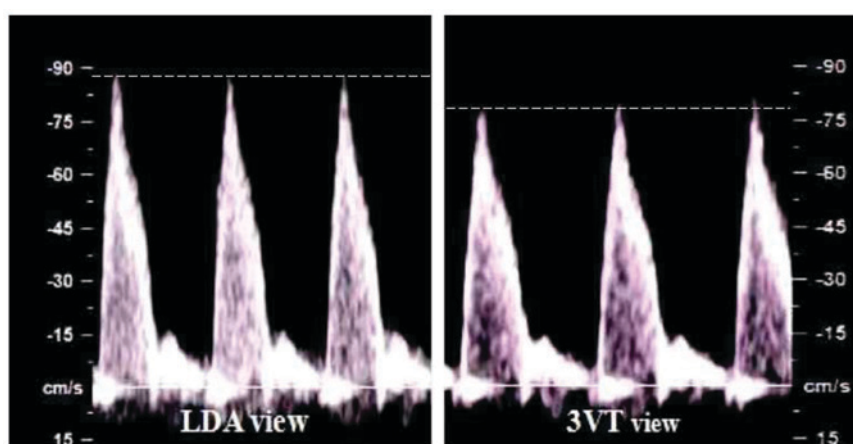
Doppler velocity waveforms of the ductus arteriosus obtained in the LDA and 3VT views of a fetus at 32 weeks of gestation. LDA, longitudinal ductal arch; 3VT, three vessels and trachea.
